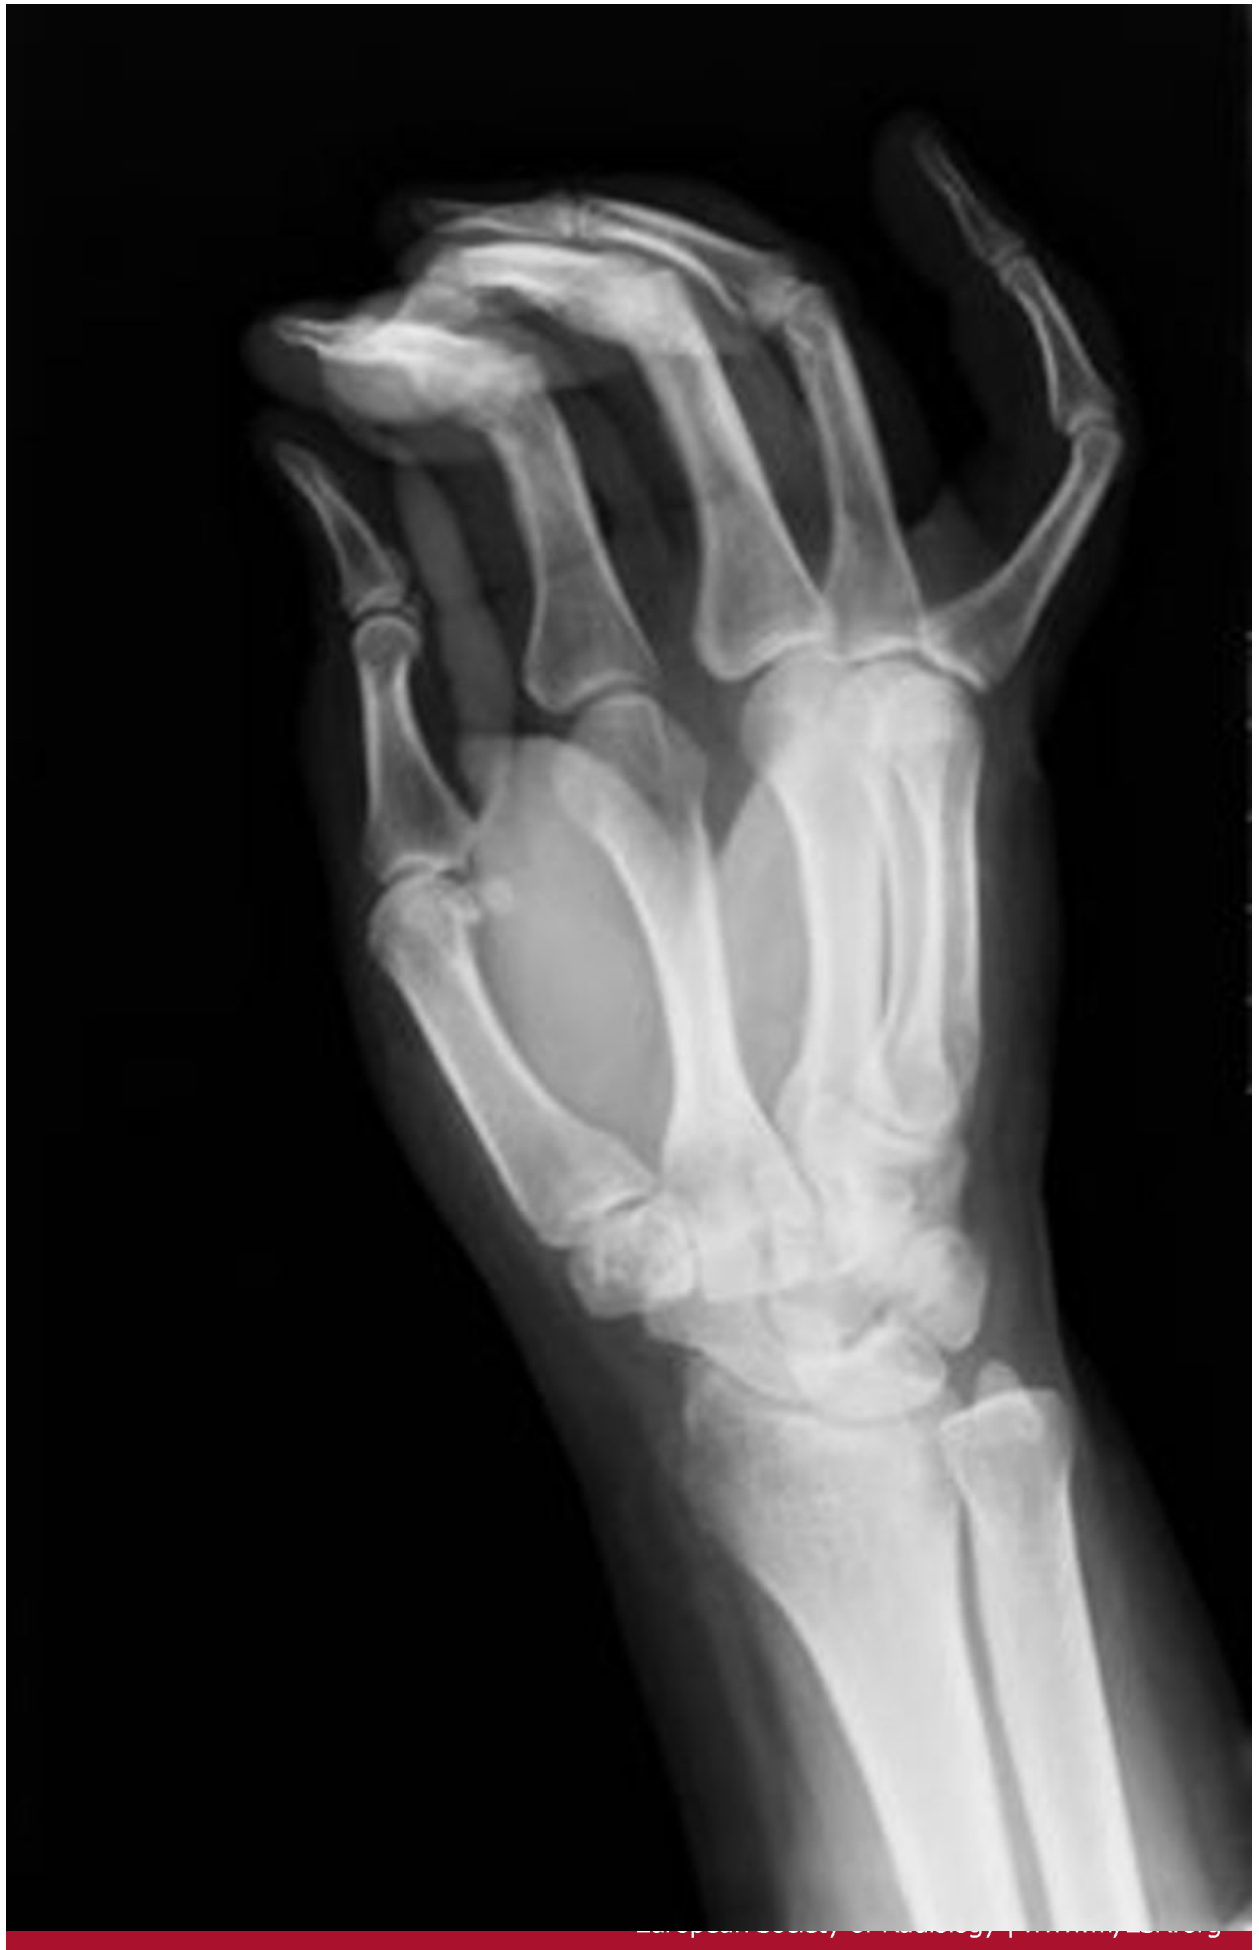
Juvenile chronic arthritis. PA radiographic view with changes in third MCP joint.
